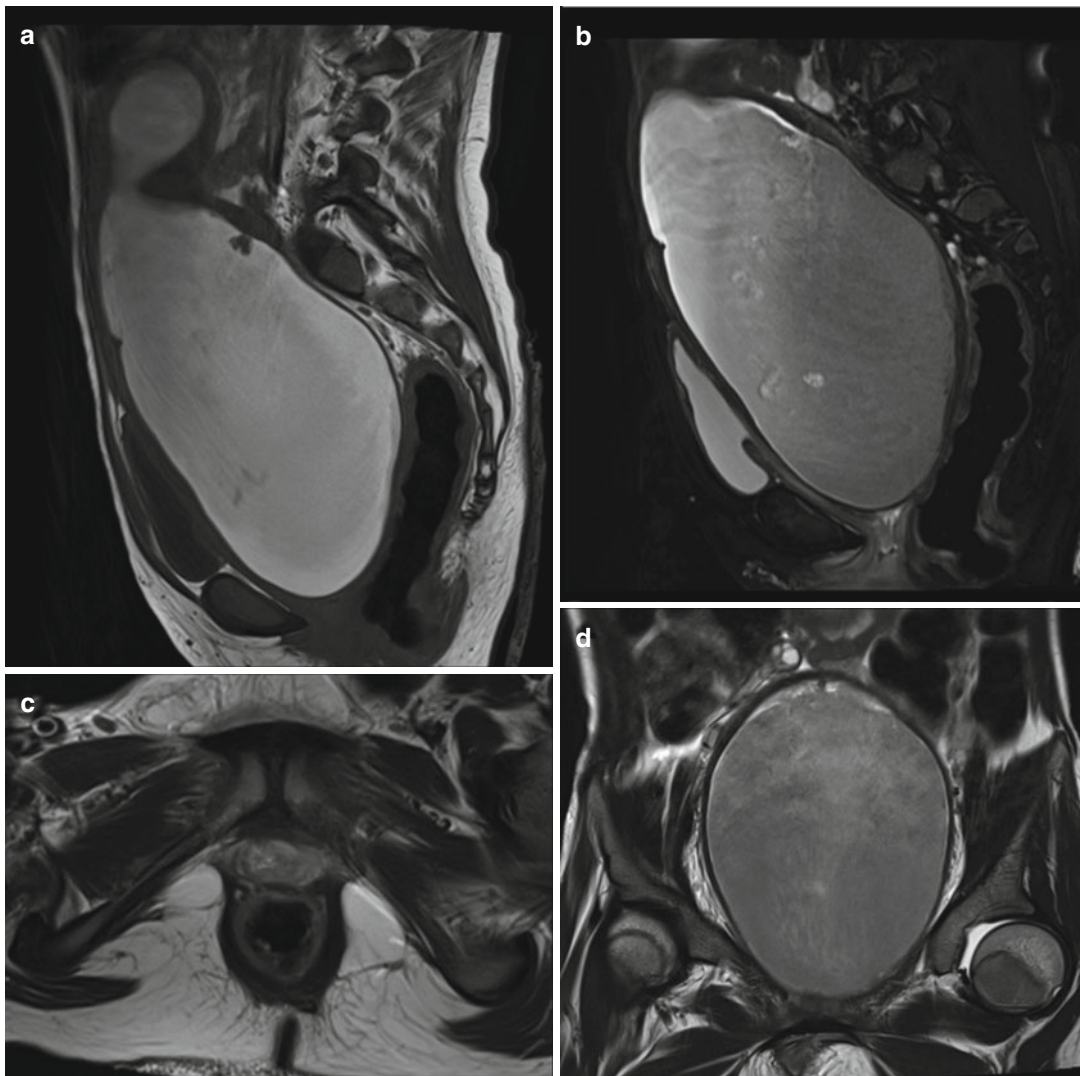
(a–d) The MRI T1-weighted sequences and T2-weighted imaging show hematocolpos/hematometra as enlarged uterine and vaginal cavities in the same patient
